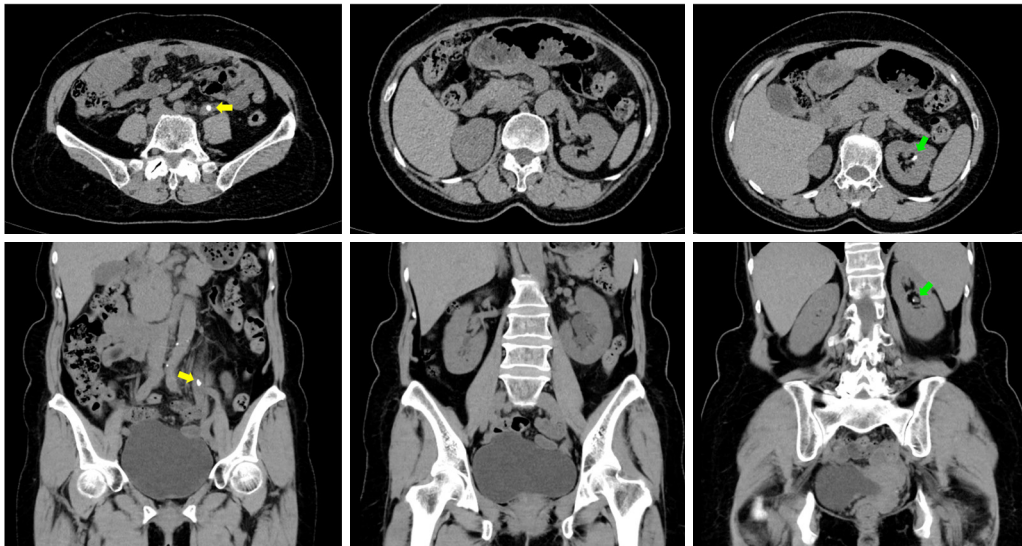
Preoperative computed tomography of the patient revealing a left duplex kidney with upper ureteric stone (yellow arrows) and renal stones (green arrows).
